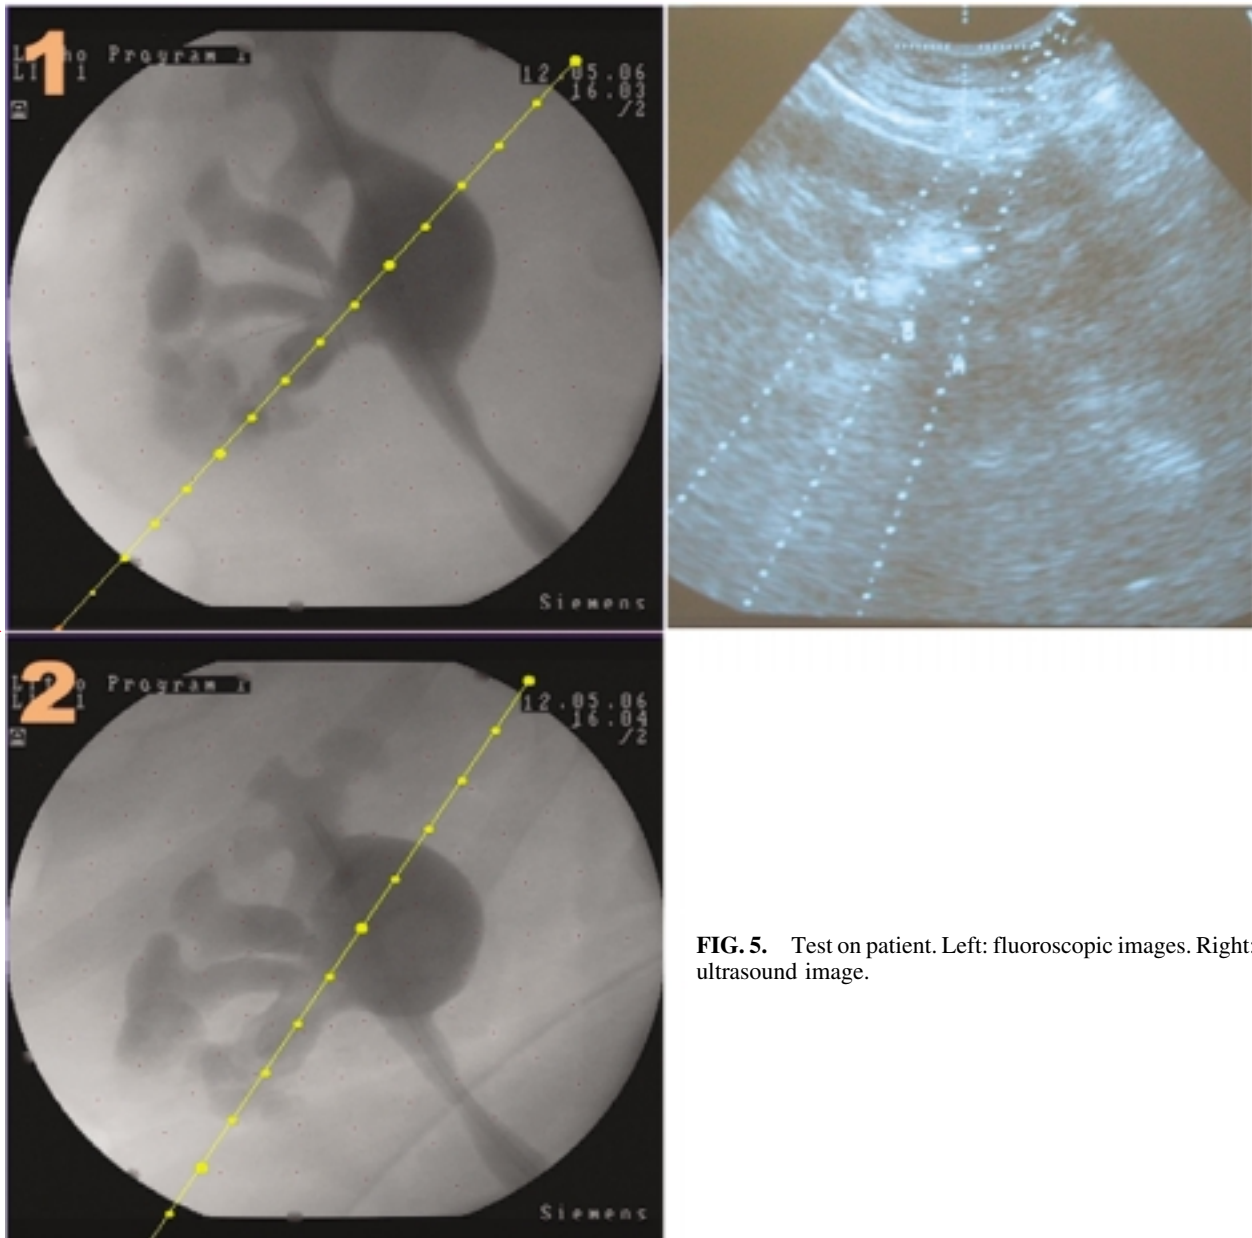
Test on patient. Left: fluoroscopic images. Right: ultrasound image.
